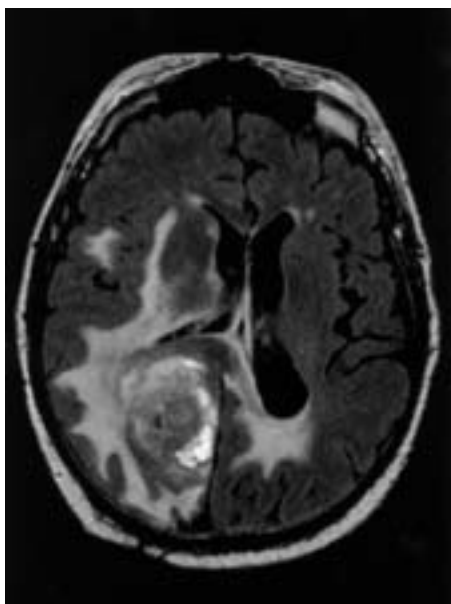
Patient with glioblastoma multiforme. The magnetic resonance image shows a contrast-enhancing tumor, edema of the adjacent brain tissue, and distortion of the ventricle.
